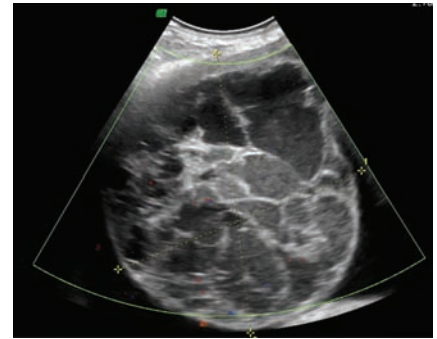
Ultrasonography showing a large multiseptate mass in the right axilla and a Doppler scanning no vascularity in the mass.
